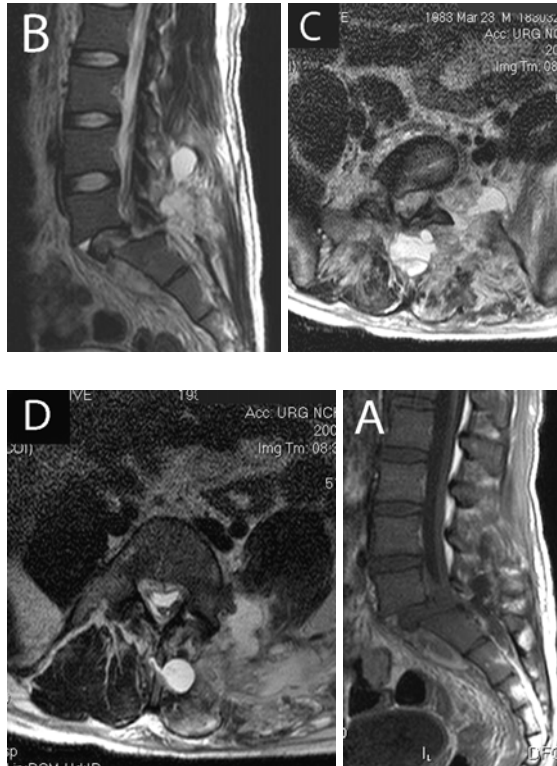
MRI scan. A, T1 weighted image; B, T2 weighted image; C, D. axial - T2 weighted image
